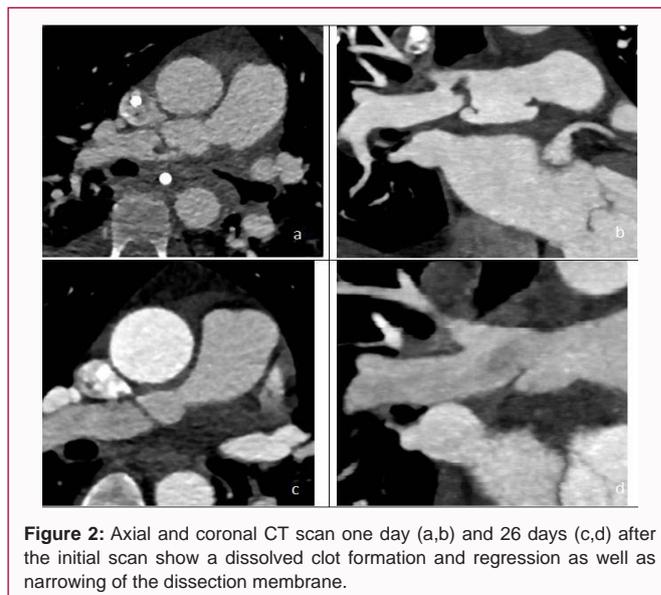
Axial and coronal CT scan one day (a,b) and 26 days (c,d) after the initial scan show a dissolved clot formation and regression as well as narrowing of the dissection membrane.
